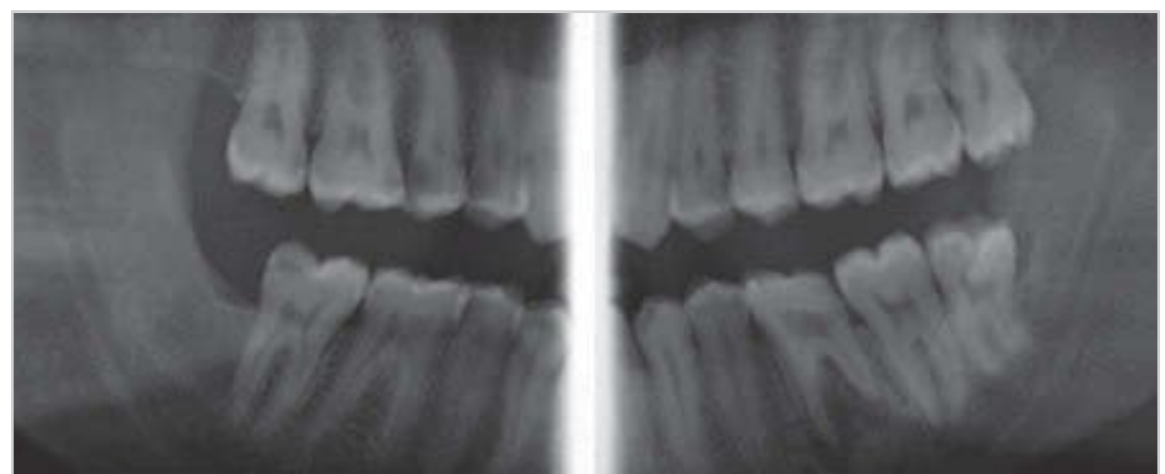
Panoramic radiography: bitewing program.
